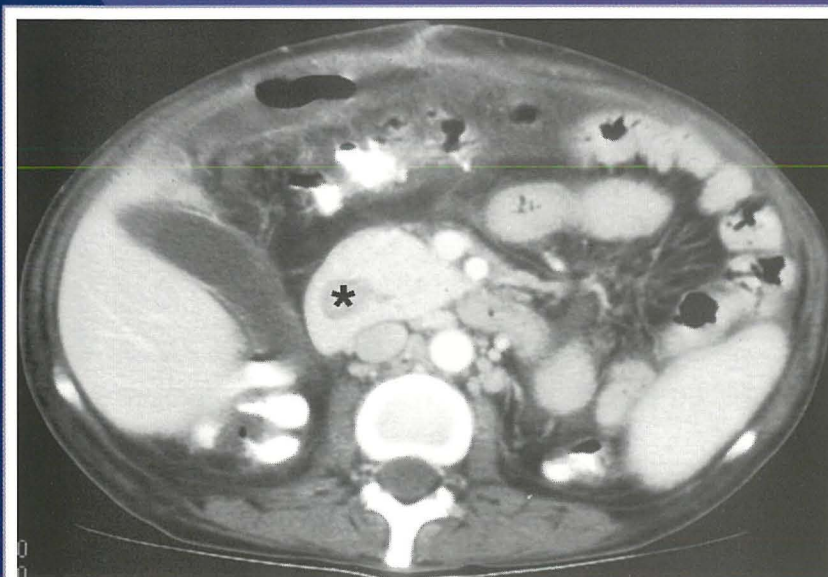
CT scan showing an annular pancreas encircling the duodenum (*).
